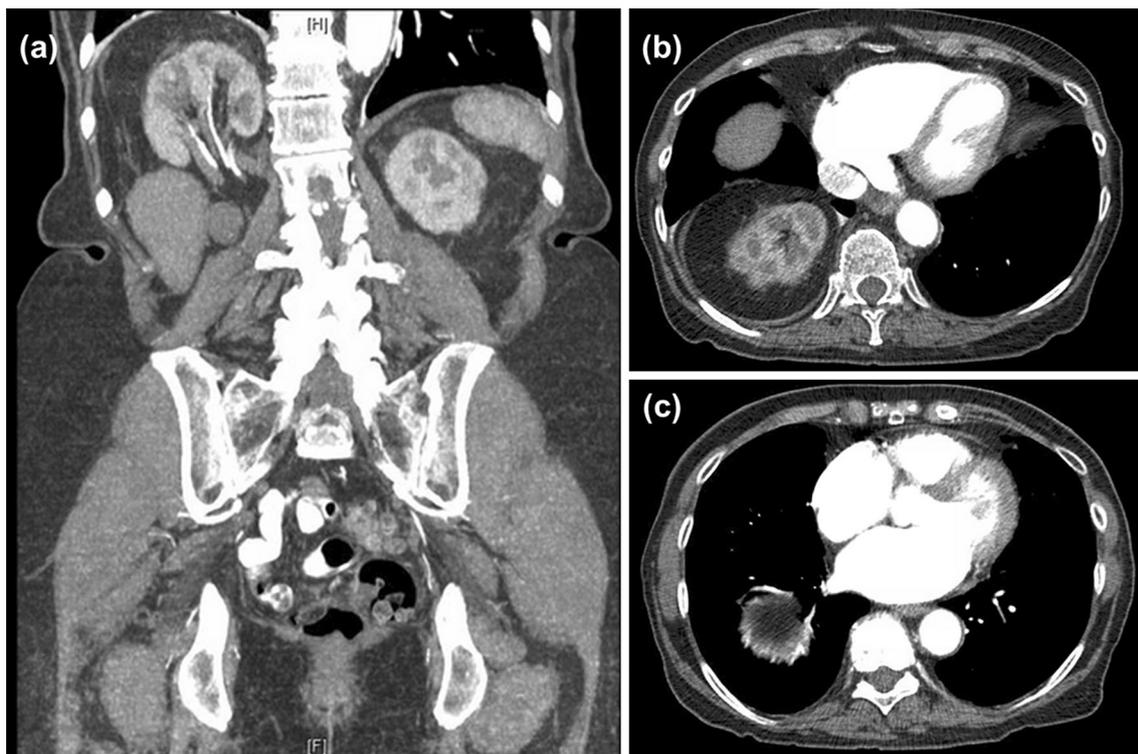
a Coronal image of computed tomographic scan showing kidney herniation through the right diaphragm. b, c Axial images demonstrating kidney herniation into the thorax
